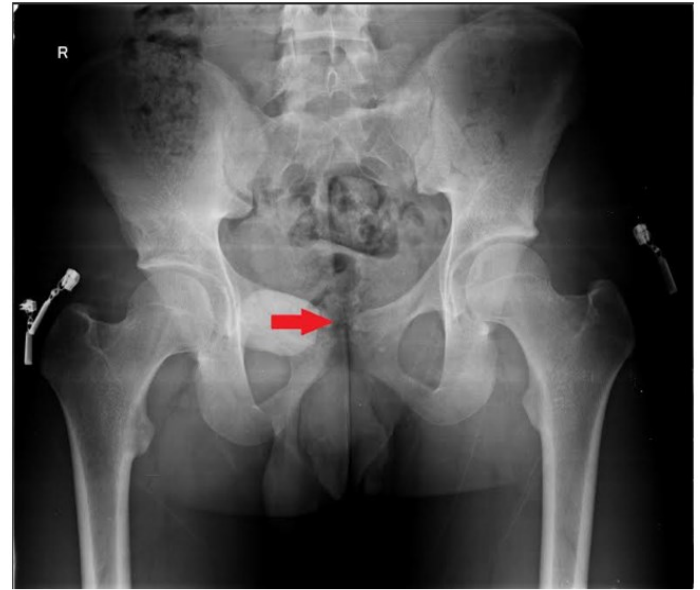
Pelvic zone radiograph taken 12 months post-operatively, demonstrating satisfactory maturation of the bone graft site (red arrow).
